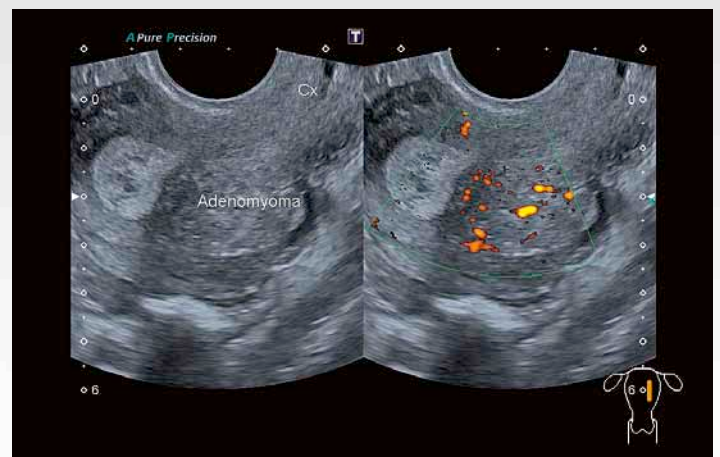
highlights increased myometrial vascularity associated with adenomyosis using colour Doppler (PD) imaging.
